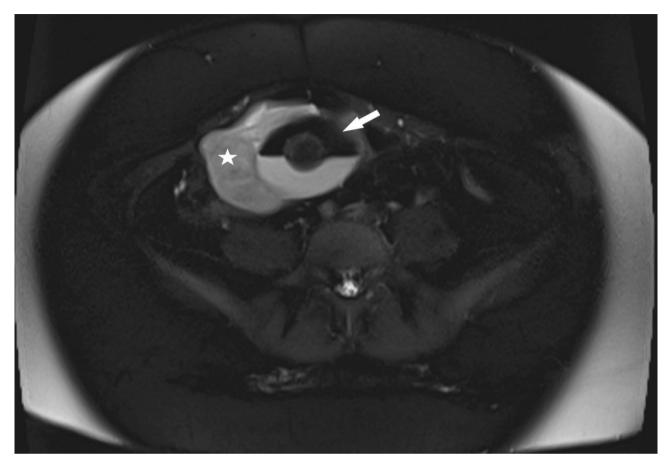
T2-weighted fat-suppressed MRI image in the axial plane showcases a clearly defined, oval-shaped lesion consistent with a mature cystic teratoma, evident by the fat-fluid levels marked with a white arrow. Adjacent to this, on the right anterolateral aspect, lies a heterogeneous, hyperintense soft tissue component, indicated by a white star, suggestive of malignant transformation
